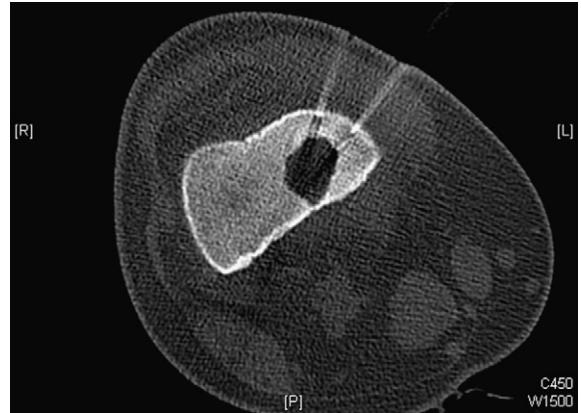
CT image showing two Bonopty needles in the abscess cavity.
